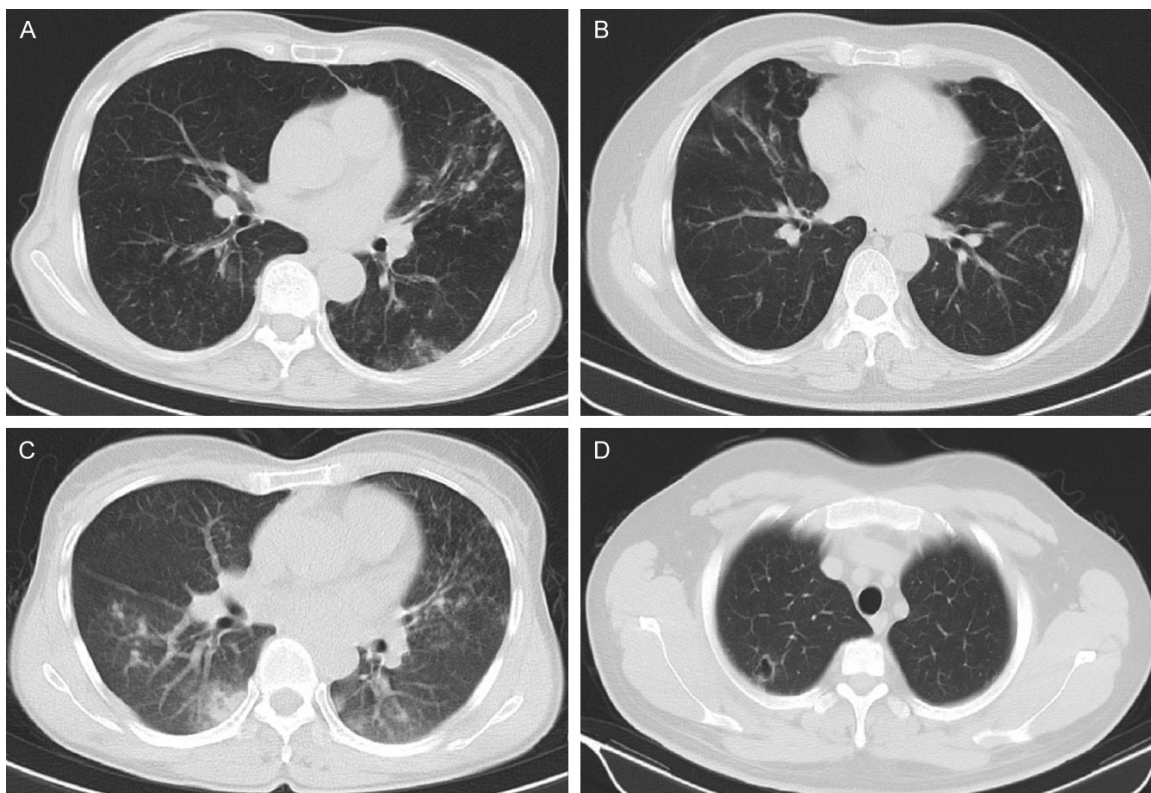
Representative chest CT images of NTM-PD patients. A. Female, 62 years old, infected with *Mycobacterium intracellulare*, showing nodules and bronchiectasis in the upper lobe of the left lung. B. Male, 47 years old, infected with *Mycobacterium intracellulare*, presenting with nodules and spot shadows in both lungs, with cylindrical bronchiectasis in some lesions. C. Female, 46 years old, infected with *Mycobacterium abscessus*, displaying nodules and spot shadows in both lungs. D. Male, 27 years old, infected with *Mycobacterium kansasii*, showing a thin-walled cavity in the upper lobe of the right lung. NTM-PD: Nontuberculous Mycobacterial Pulmonary Disease.
